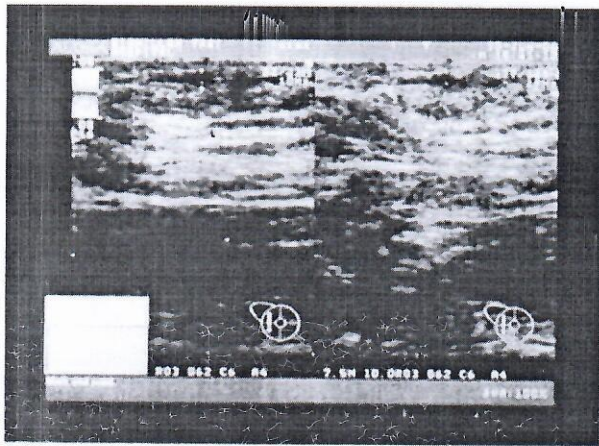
High frequency ultrasound of the axilla showing the fistula tract.
